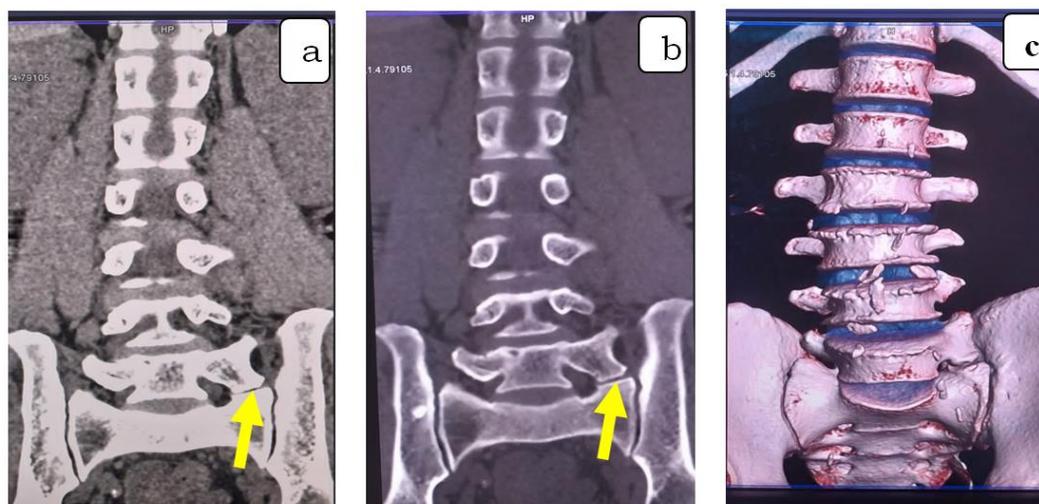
H of 55 years, CT in coronal reconstruction (parenchymal and bone) and 3D objectifying a low back of S1 type II a (arrow)
